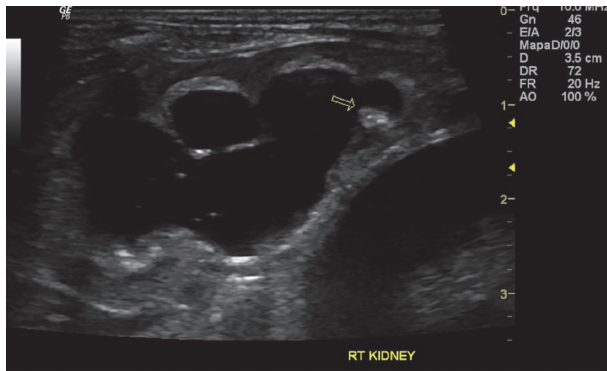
Ultrasonographic evaluation of the second patient performed at 58 days of life demonstrating a hyperechogenic oval image suggestive of a fungal ball in the lower calyx group of the right kidney (delimited by the yellow arrows), besides hydronephrosis with a non-homogeneous urinary content.
